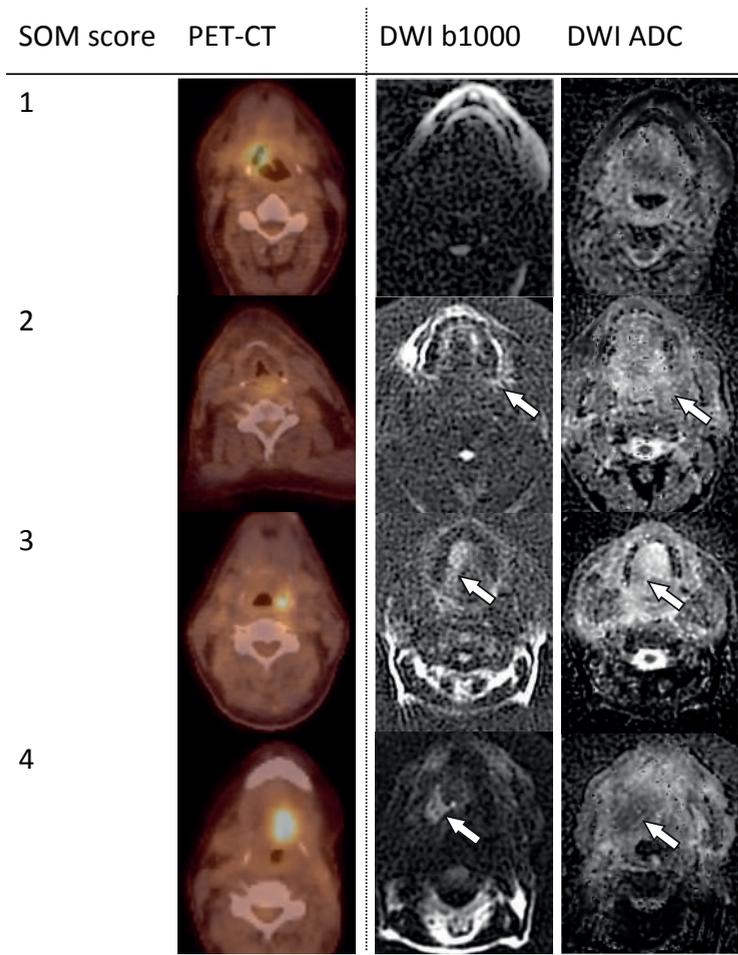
Axial images for each SOM score for PET-CT and DWI. As both modalities were assessed independently, PET-CT and DWI images with identical SOM scores are not from the same patients. The arrows mark the area of diffusion restriction.
